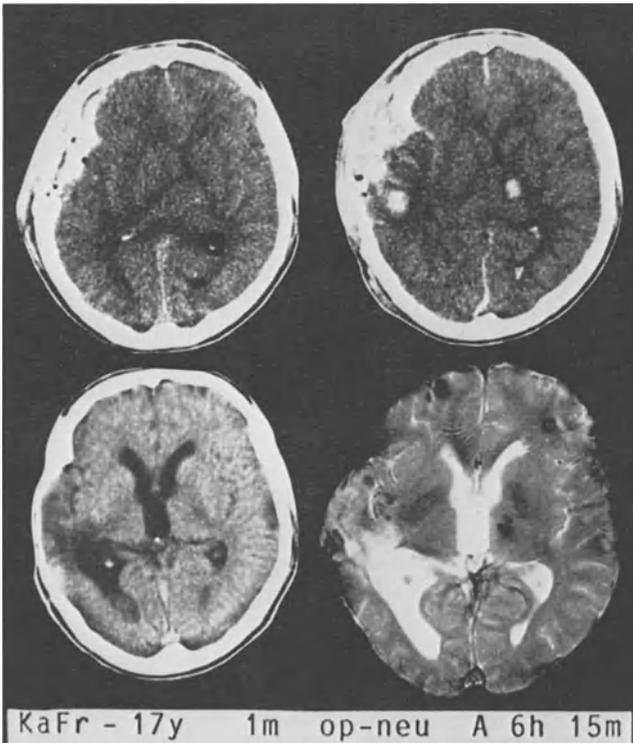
Imaging of posttraumatic intracranial bleedings: acute subdural, subarachnoid, intracerebral (intraventricular). Follow-up with CT compared to MRI after 15 months. The hemorrhage of the right basal ganglia increased during the first posttraumatic hours; after 15 months the residua are less evident in CT than in MRI (black spots). Additional reduced signal intensities (black) are seen at the frontal left, in front of the right cornu arterius, and at the temporal right (residua of posttraumatic subarachnoid hemorrhage?, contrecoup?). There are no gross rub-off artifacts after craniotomy. KaFr, initials; 17 y, age at the time of accident: 17 years; 1 m, 1 month of posttraumatic coma; op-neu, operation because of left-sided space-occupying subdural hematoma; A, CT on admission (upper left); 6 h, postoperative CT after 6 h (upper right); 15 m, reexamination after 15 months by CT (lower left) and MRI (lower right). Clinical outcome: disabled but independent. EEG: theta-delta focus, temporal left. Note: Here, as in other figures, "patient's left" = viewer's left
